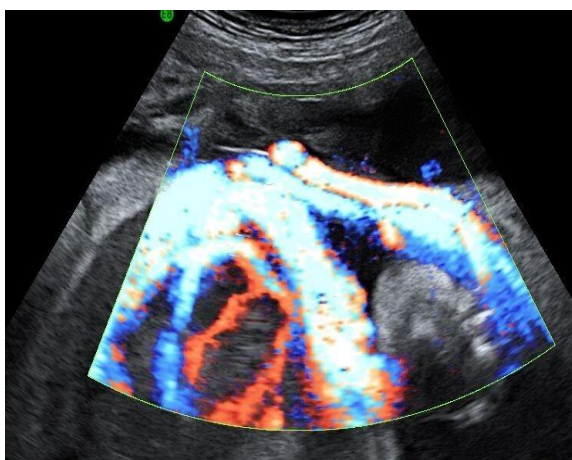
Color Doppler (Placental Chorioangioma)
